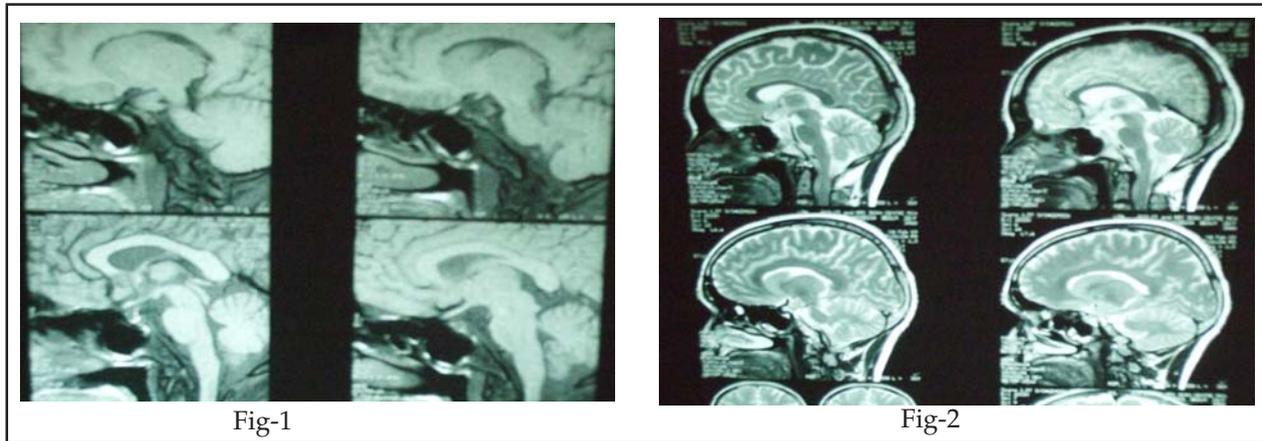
MRI brain and pituitary fossa showing empty pituitary fossa/ empty sella.
